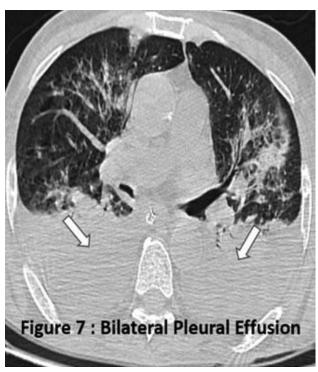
HRCT Axial image showing GGO and pleural effusion
